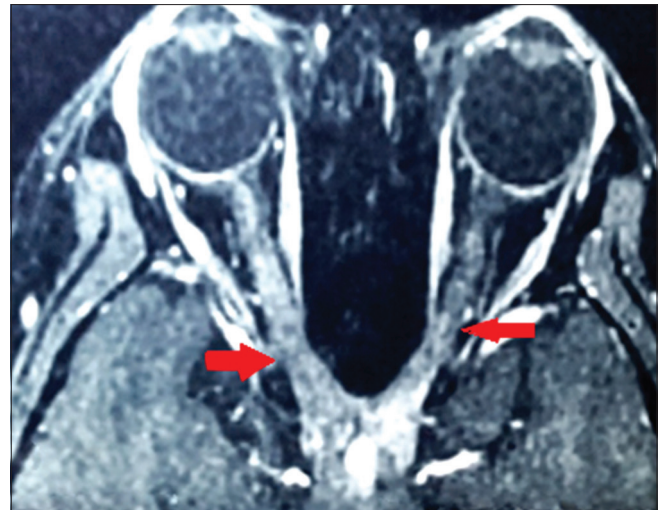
Magnetic resonance imaging brain and orbits axial cut showing T2 hyperintense signal in the bilateral optic nerves with enlarged intracranial optic nerves and chiasm with infundibulum thickened
